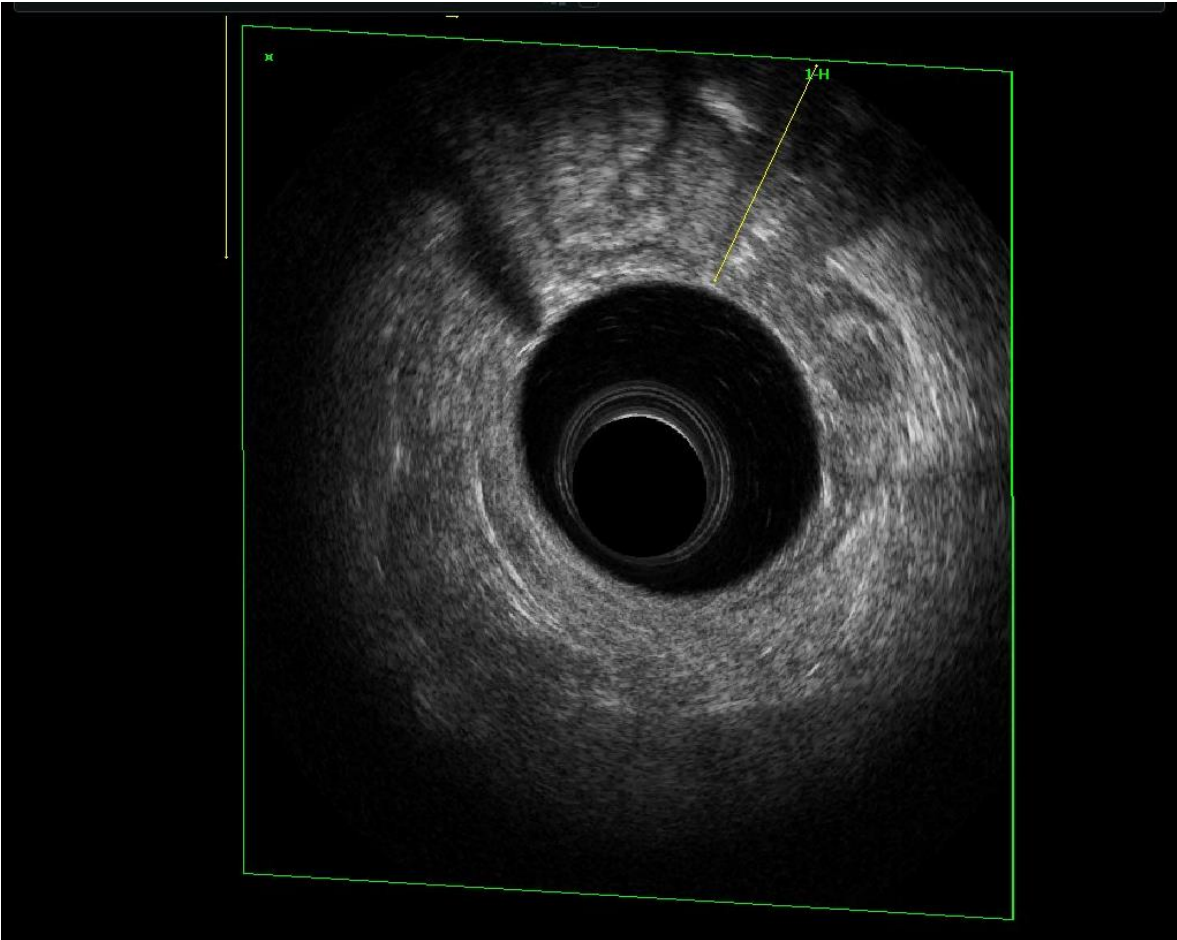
(Case 202) Endoscopic ultrasound (EUS) in a 65-year old patient which showed a mid-rectal hypoecogenic lesion that affected the perirectal fat, with one pathological lymph node and classified as an uT3N1a tumour. However, the test was unsatisfactory due to the stenotic nature of the lesion, a common shortcoming of EUS. The MRI performed showed a cT3bN2b with a threatened mesorectal fascia
